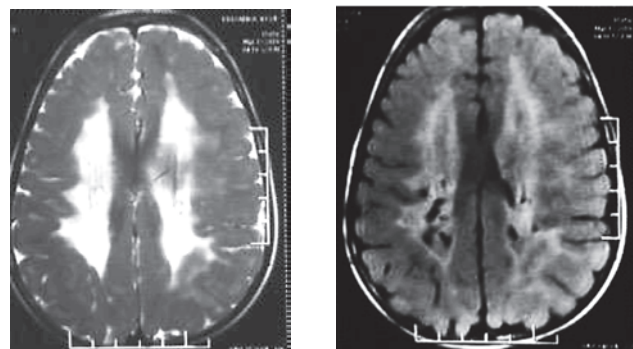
a&b. T2, FLAIR images show cavitating white matter involvement with sparing of subcortical white matter.
